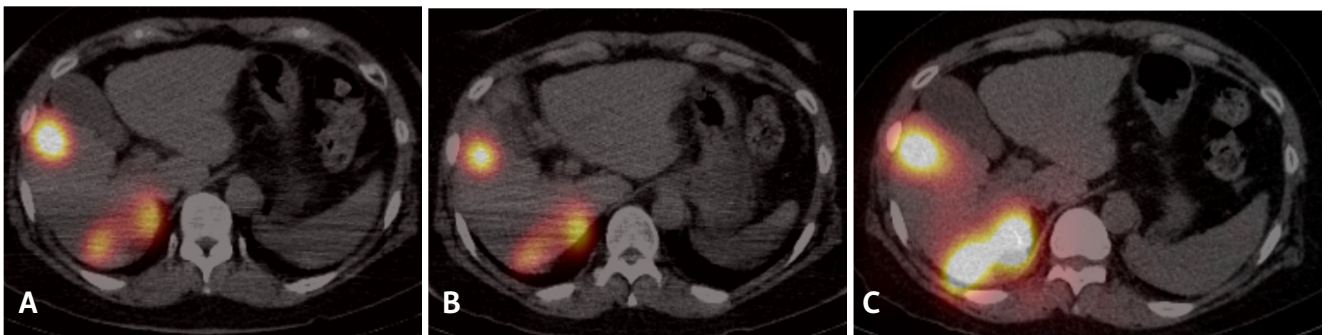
Post MAA delivery, SPECT-CT demonstrated localization of MAA to (A) the expected segment 5 and (B) segment 7 regions with 3.8% lung shunt. (C) Post Y-90 radioembolization SPECT-CT demonstrated localization of Y-90 glass beads to the expected segment 5 and 7 regions without extrahepatic distribution.
